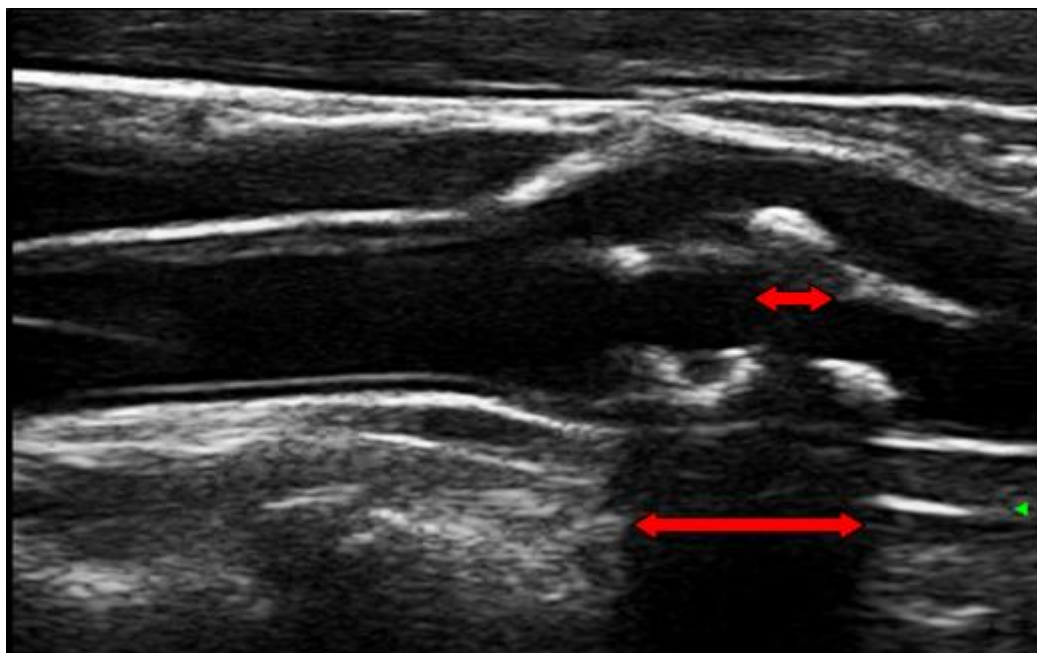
Ultrasonographic image representing the length of an acoustic shadow (LAS) generated by calcified carotid plaques.
